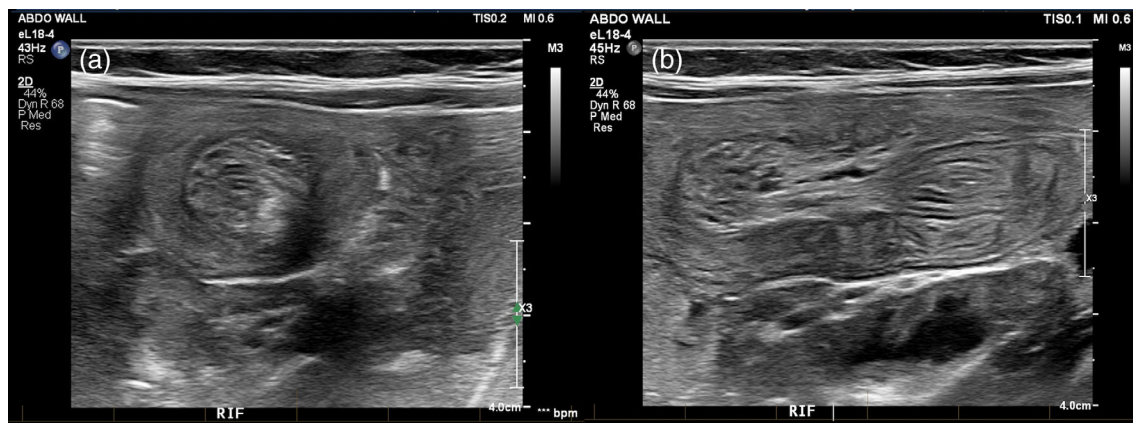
Radiology performed ultrasound images of an ileocolic intussusception in a 13-month-old infant demonstrated in both (a) transverse and (b) longitudinal views.
